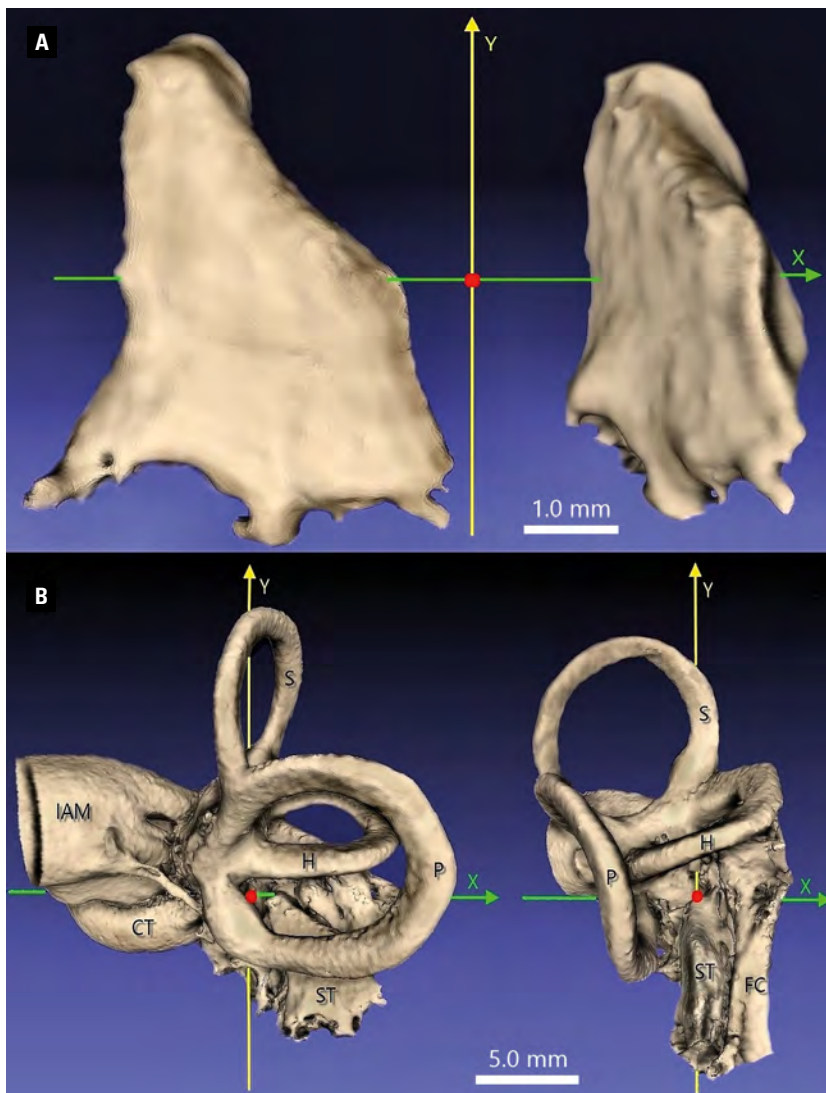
A. The three-dimensional (3D) model of the specific saccular type of sinus tympani (ST) resembling a tetrahedron in shape, seen in both lateral and posterior projection; B. A 3D model displaying topography of the ST in reference to the semicircular canals: posterior (P) — horizontal (H), superior (S) and the facial canal (FC); the cochlear turn (CT) and the internal acoustic meatus (IAM) were also identified.
